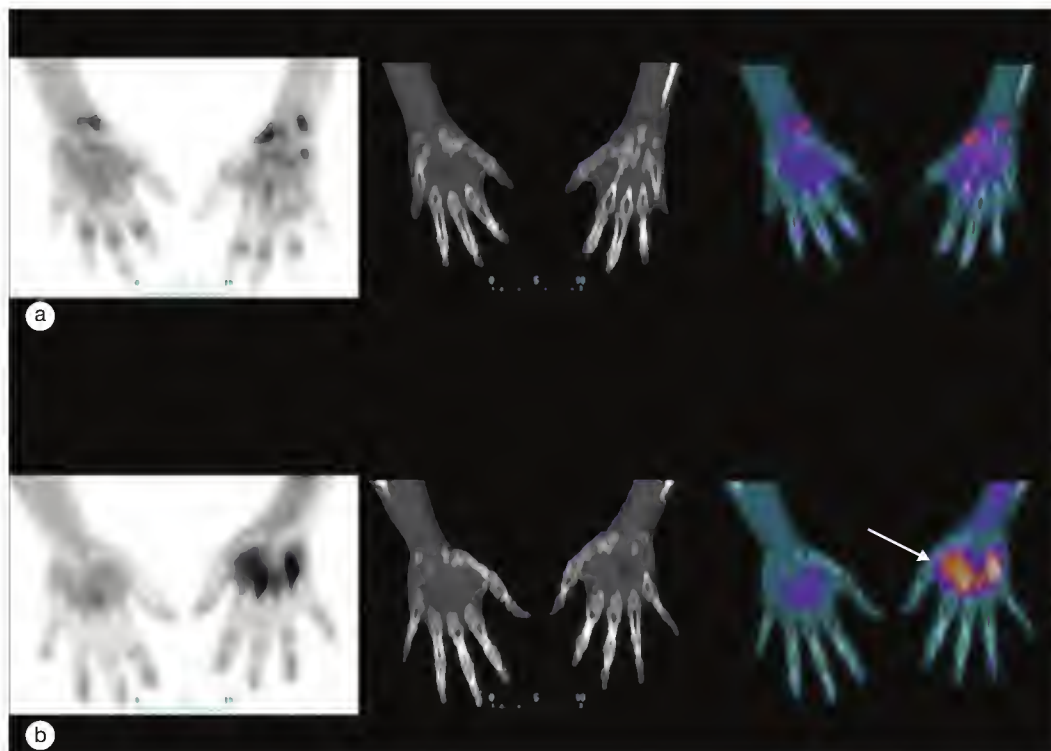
^{18}F -fluorodeoxyglucose positron emission tomographic (^{18}F -FDG-PET), computed tomographic (CT), and fused PET/CT coronal slices of the distal upper extremities in a patient with rheumatoid arthritis. (a) Inflammatory involvement of several proximal interphalangeal joints of both hands and multiple joints of both wrists. (b) Response to rituximab treatment. After 16 weeks, there is a complete metabolic response in the wrists and a partial response in the interphalangeal joints. Zones of relative hyperactivity in the left hand (arrow) correspond to physiologic muscle uptake.
